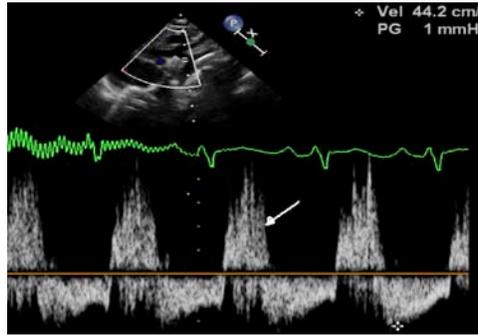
Doppler interrogation of the transverse arch shows retrograde systolic flow (white arrow); this finding indicates ductal-dependent systemic circulation.
